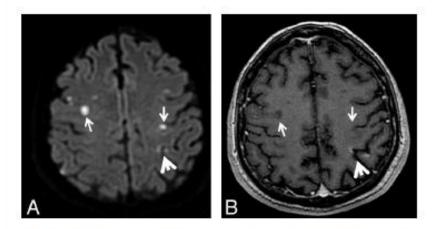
DWI (A) and postcontrast TI (B) sequences show recent ischemic lesions of different ages in the same patient; acute ischemia (small white arrows) and subacute ischemia (large white arrows).
